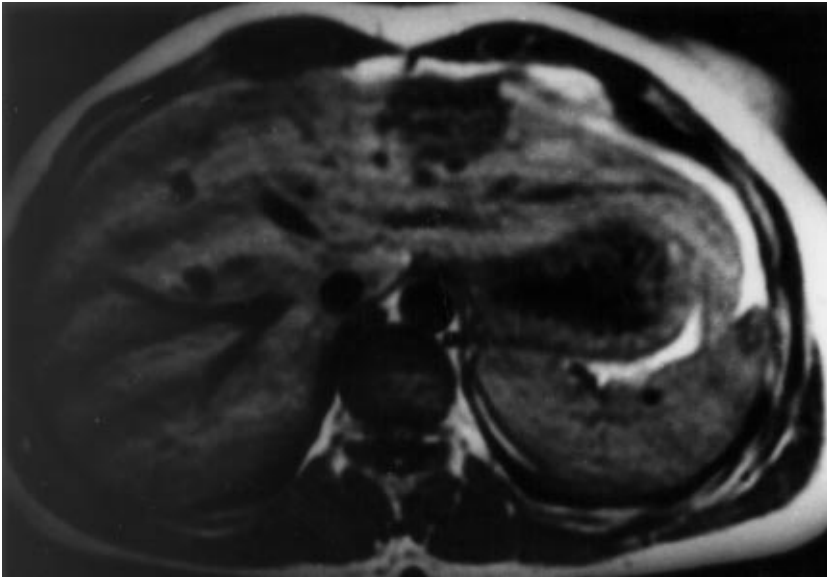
On a T1-weighted axial magnetic resonance image (TR/TE=665/20 msec), the lesion was hypointense compared to the liver parenchyma.
